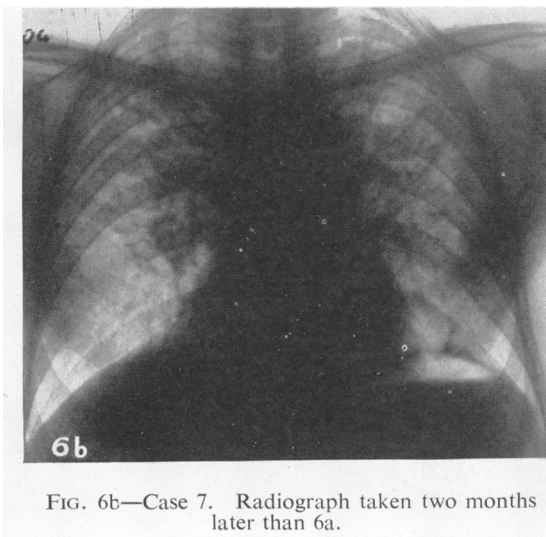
Case 7. Radiograph taken two months later than 6a.
